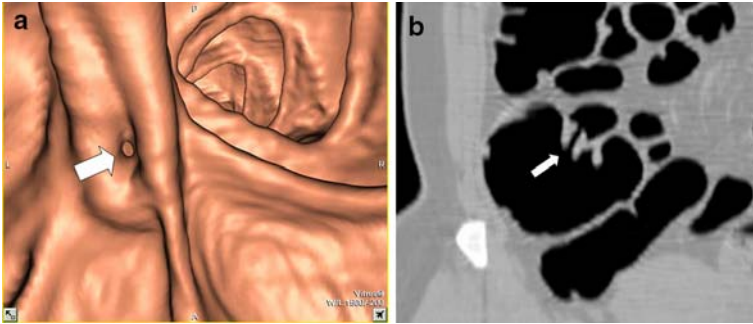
45-year-old man with open ileocecal valve. A Three dimensional threshold-rendered endoluminal CT colonograph of ascending colon shows an opening in the expected region of ileocecal valve (*arrow*). Differential diagnosis comprises
